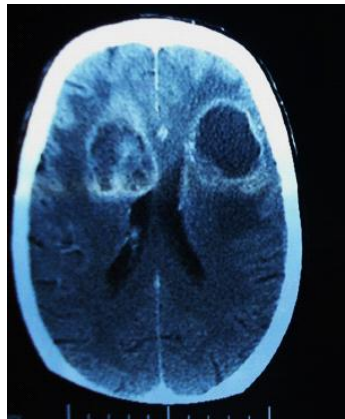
CT image of bilateral metastases
